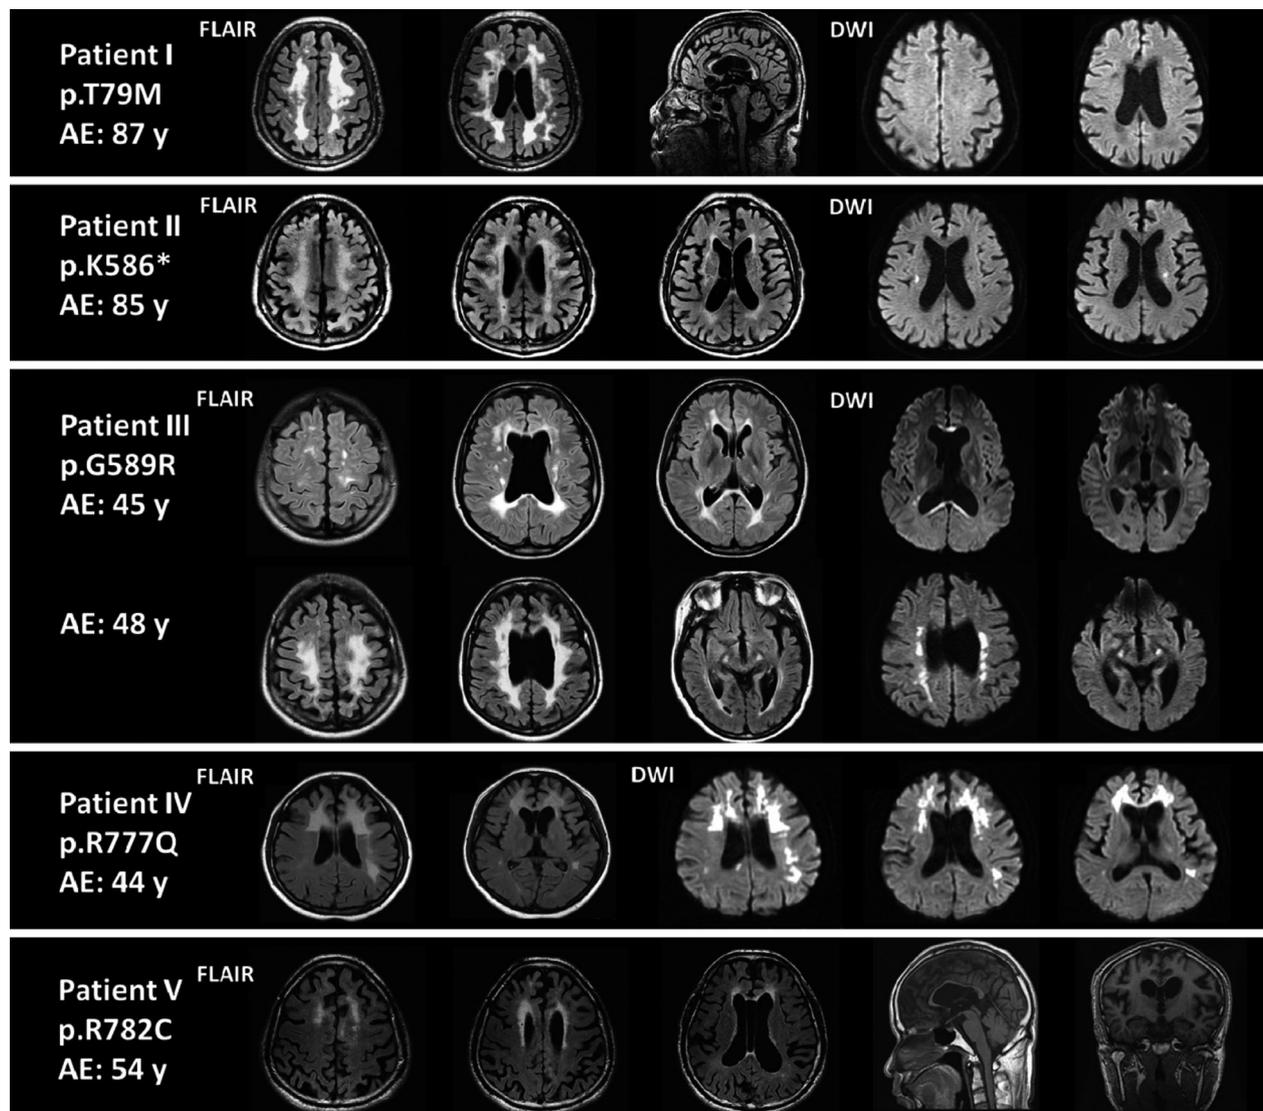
Representative magnetic resonance imaging of the patients with *CSF1R*-related leukoencephalopathy. AE, age at the examination; FLAIR, fluid-attenuated inversion recovery; DWI, diffusion-weighted imaging.
